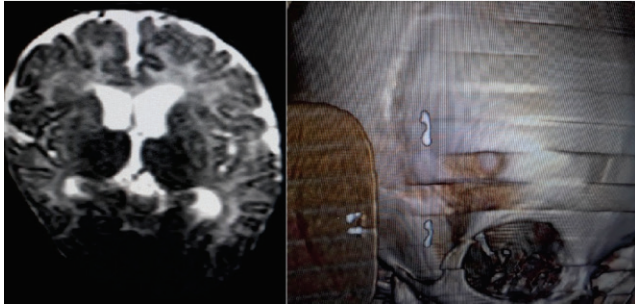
X-ray Brain axial T2W sequence showing hyperintense signal in cerebral white matter with bilateral T2 hypointense thalami. Volume rendered reformed Computed Tomography image of skull showing fusion of coronal suture and craniostenosis
